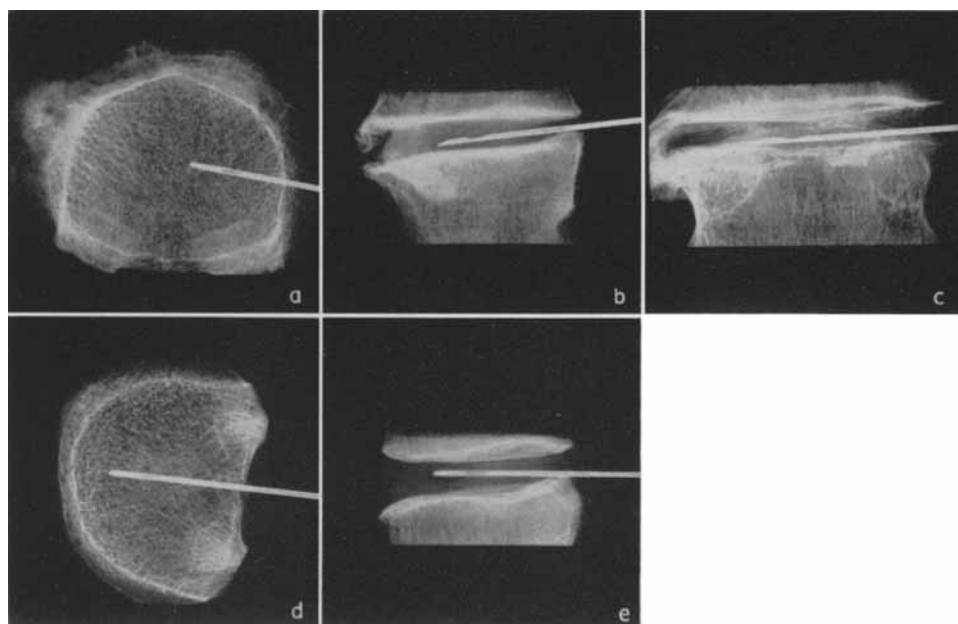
Roentgenographic appearance of the discs 593/59 – L 3 (a, b and c) and 292/58 – L 3 (d and e), shown in fig. 16. These roentgenograms show clear signs of disc degeneration (+). Scale 1:2.
